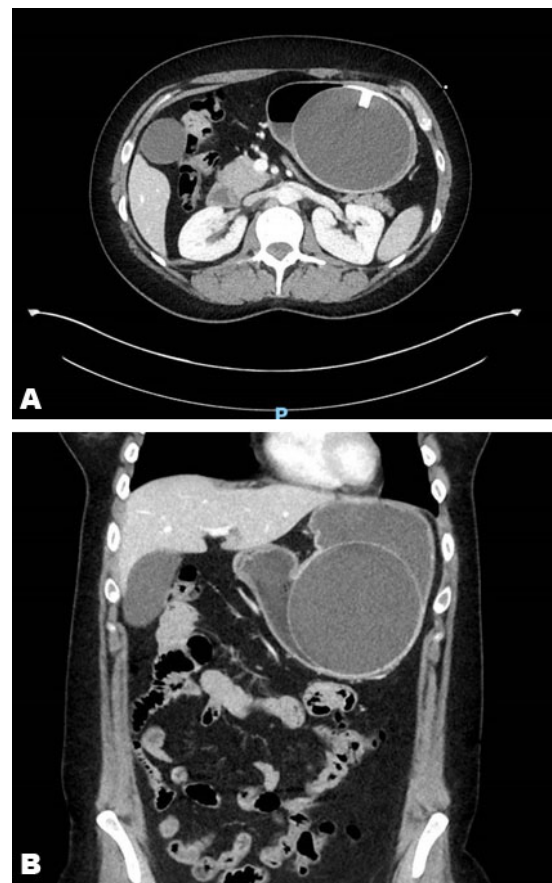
(A and B) Axial view of CT scan showing intragastric balloon in situ with no active bleed. (A) Coronal view of abdomen and (B) axial view of abdomen.
